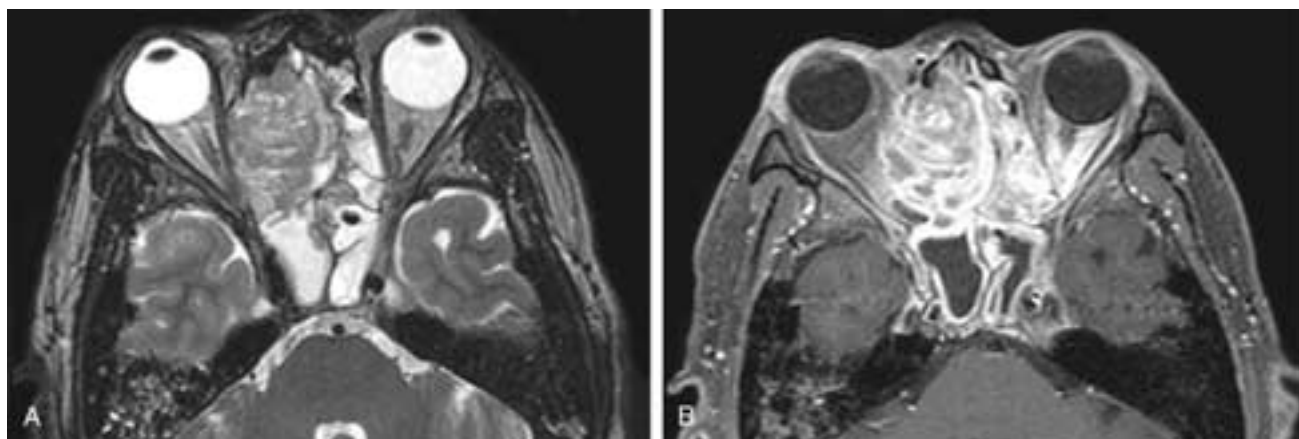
Axial T2-weighted (A) and T1-weighted, fat-suppressed, contrast-enhanced MR images show a destructive mass in the right ethmoid complex and right orbit. Tumor extends into the left ethmoid complex. In B, there is poor separation of the tumor and any obstructed secretions in the left ethmoid cells. However, in A, this distinction is clear. There was no invasion of the left orbit. The sphenoid sinuses were obstructed. This patient had a squamous cell carcinoma.
